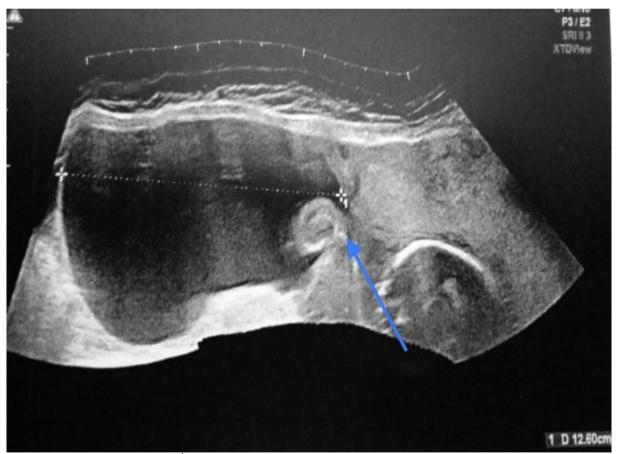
Ultrasound image at 21st weeks of gestation showing a significant herniation of the amniotic sac through a defect of the right uterine wall with a height of 12.60 cm.
